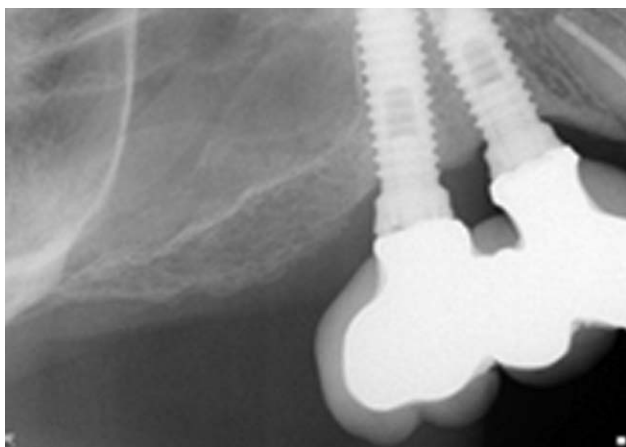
Periapical view 9 years after loading.
